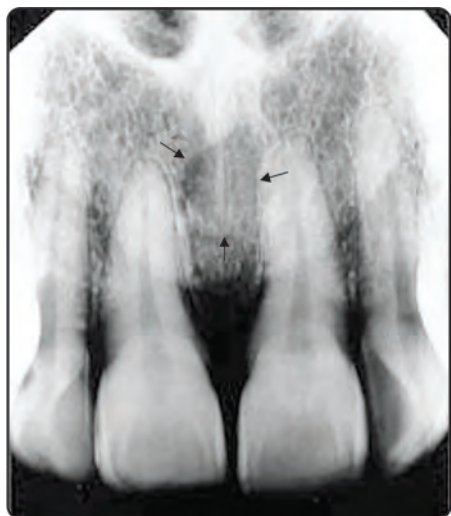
Intraoral periapical radiograph of maxillary central incisor showing nasopalatine canal between central incisors
